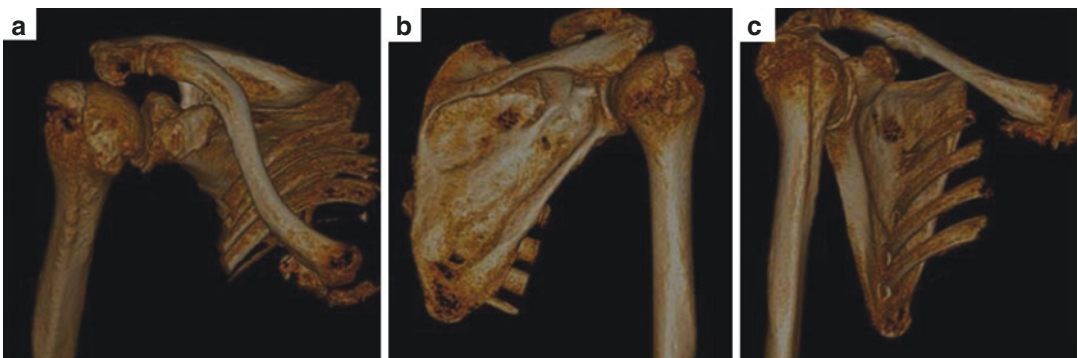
CT-3D reconstruction (right shoulder). (a) Antero-posterior view. (b) Posterior view. (c) Anterior oblique view
